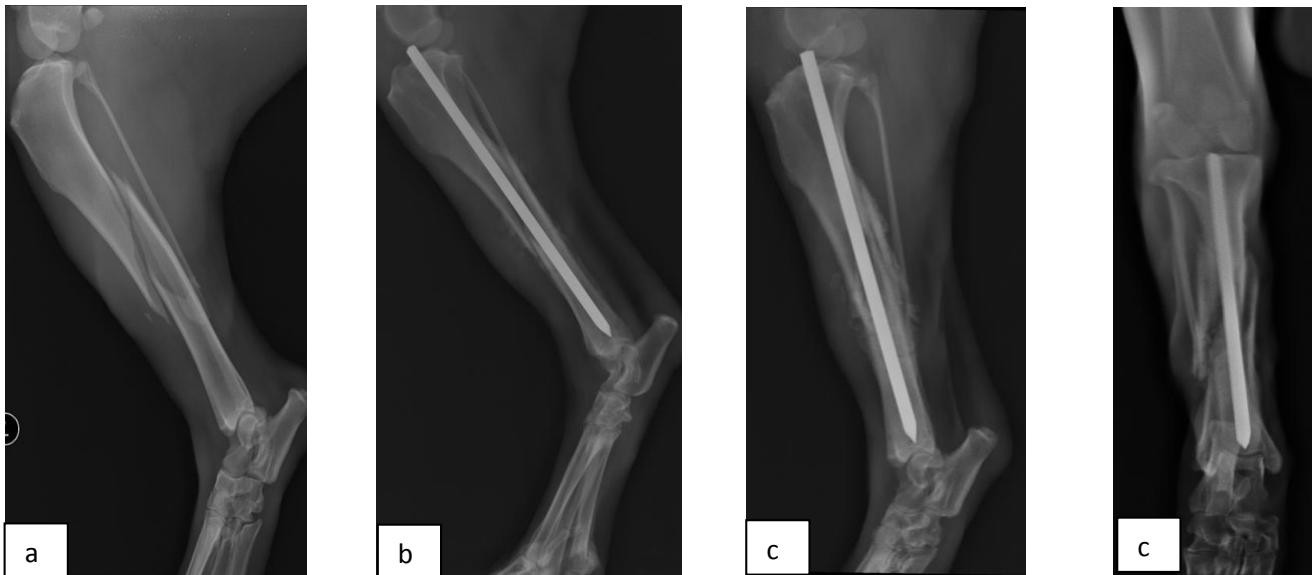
(c) 60 days and (d) 75 days post-operative medio-lateral and cranio-caudal radiographs showing sequence of fracture healing.
